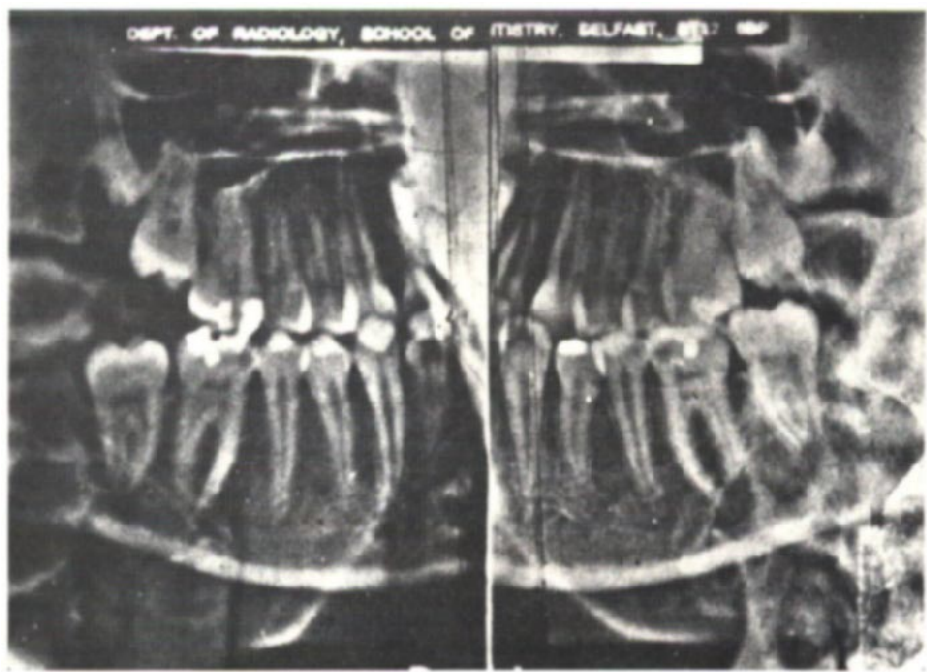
Radiograph of patient shown in Figure 1. Note absence of developing lower right third molar.
